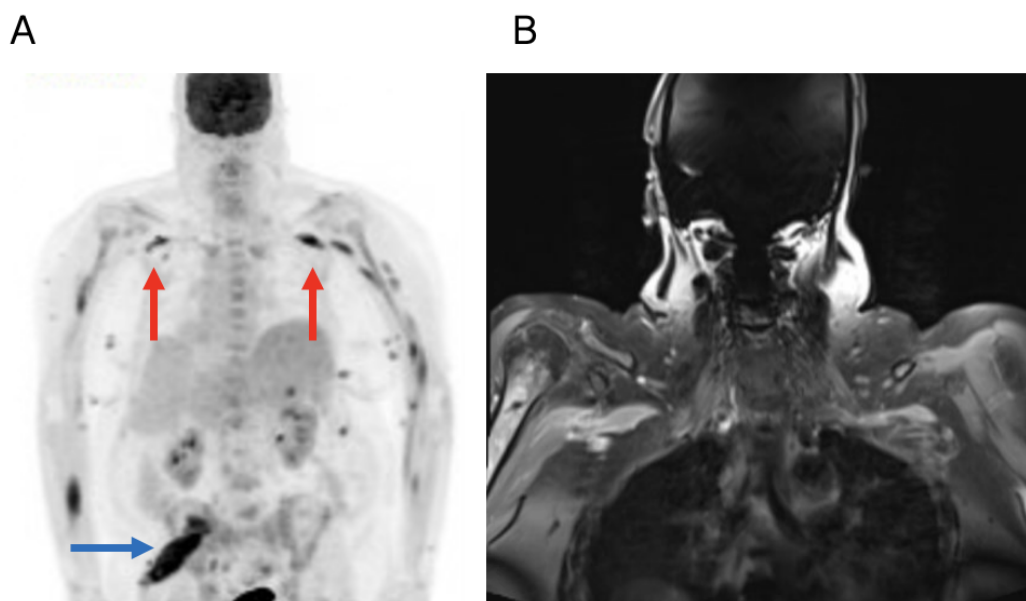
(A) PET scan showing small left supraclavicular and subpectoral lymph nodes (red arrows) and muscular invasion, greatest involving the left gluteus maximus (blue arrow), (B) MRI showing segmental regions of thickening and enhancement along the distal cords and axillary branches of the right brachial plexus.
